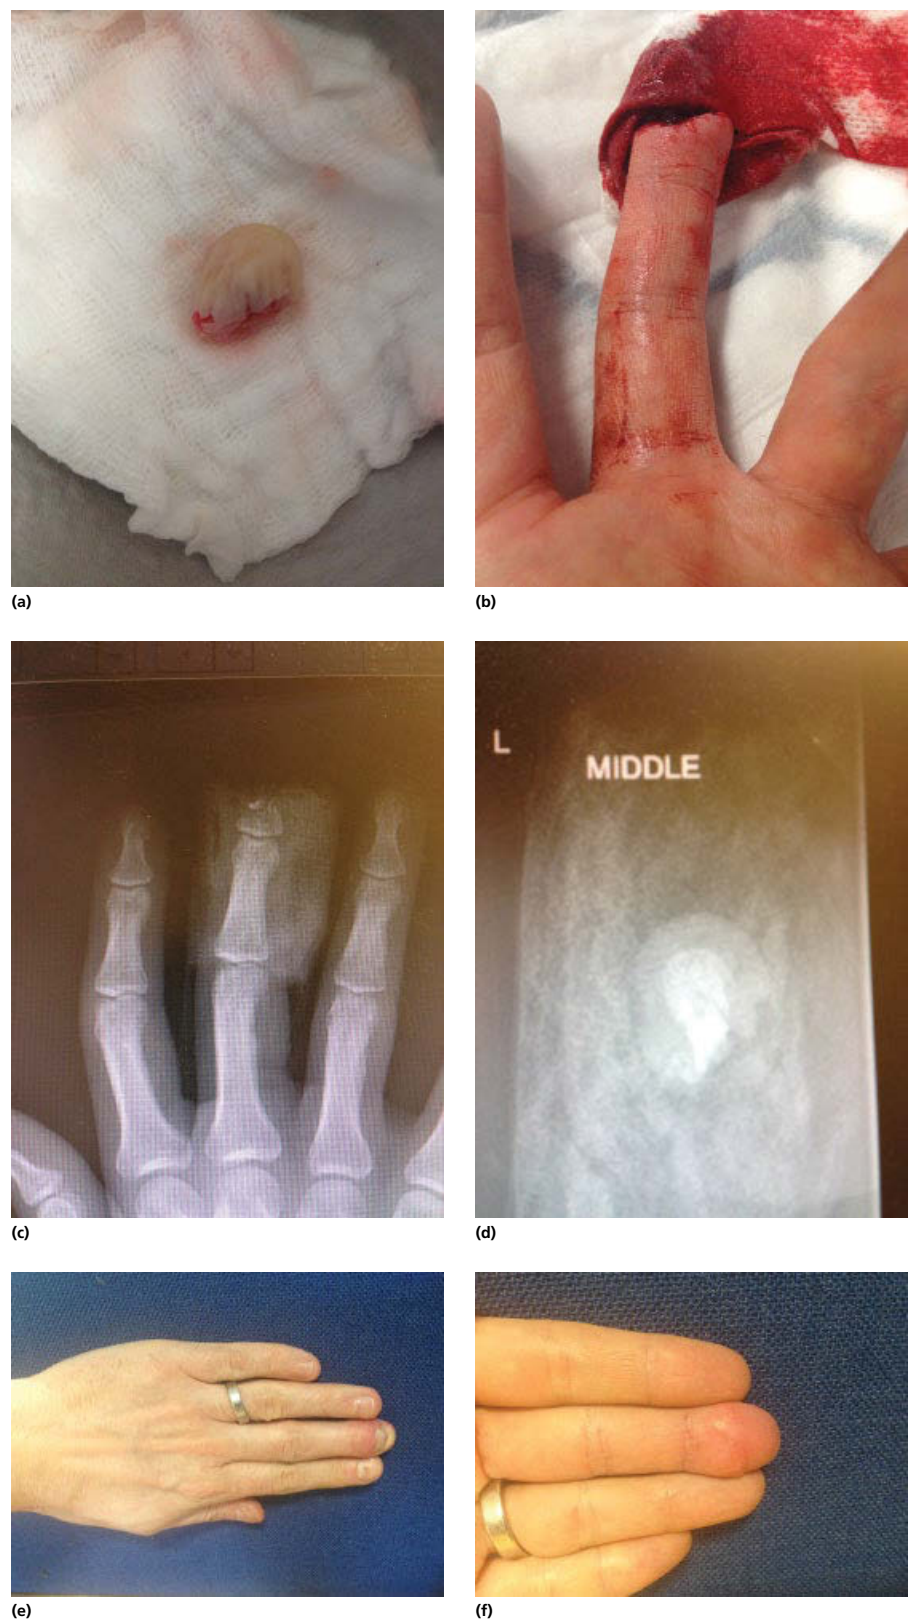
(a) Amputated distal tip of middle finger. (b) Proximal finger with amputated tip. (c) Finger X-ray demonstrating amputation level. (d) X-Ray of amputate. (e, f) Replanted finger at two weeks.
